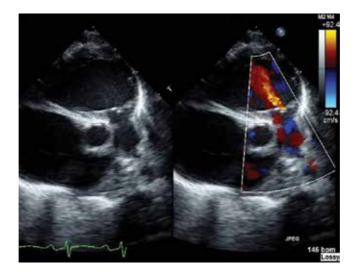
Color compare parasternal short axis view demonstrates the small functional right ventricle and pulmonary atresia. The tricuspid valve is rotated in a fashion that the effective orifice opens to the right ventricular outflow tract. Color Doppler demonstrates swirling of blood in the functional right ventricle, tricuspid regurgitation, and no antegrade pulmonary blood flow. aRV: Atrialized right ventricle.
